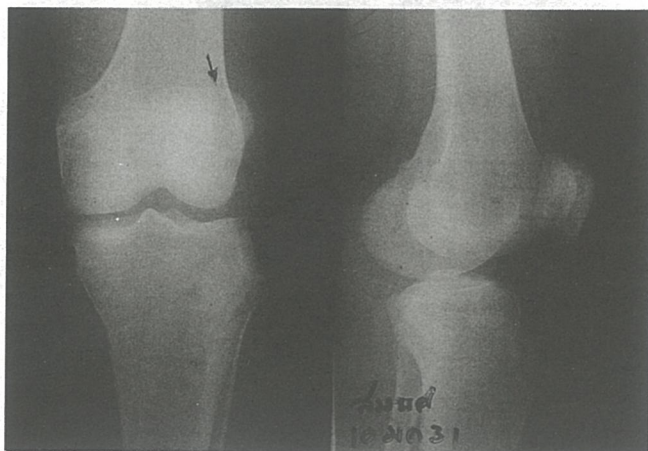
Anteroposterior roentgenogram of the left knee shows vertical fracture of the lateral pole of patella. (arrow)
